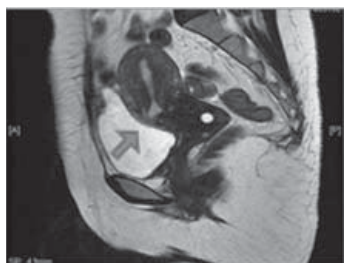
MRI picture showing Isthmoele
